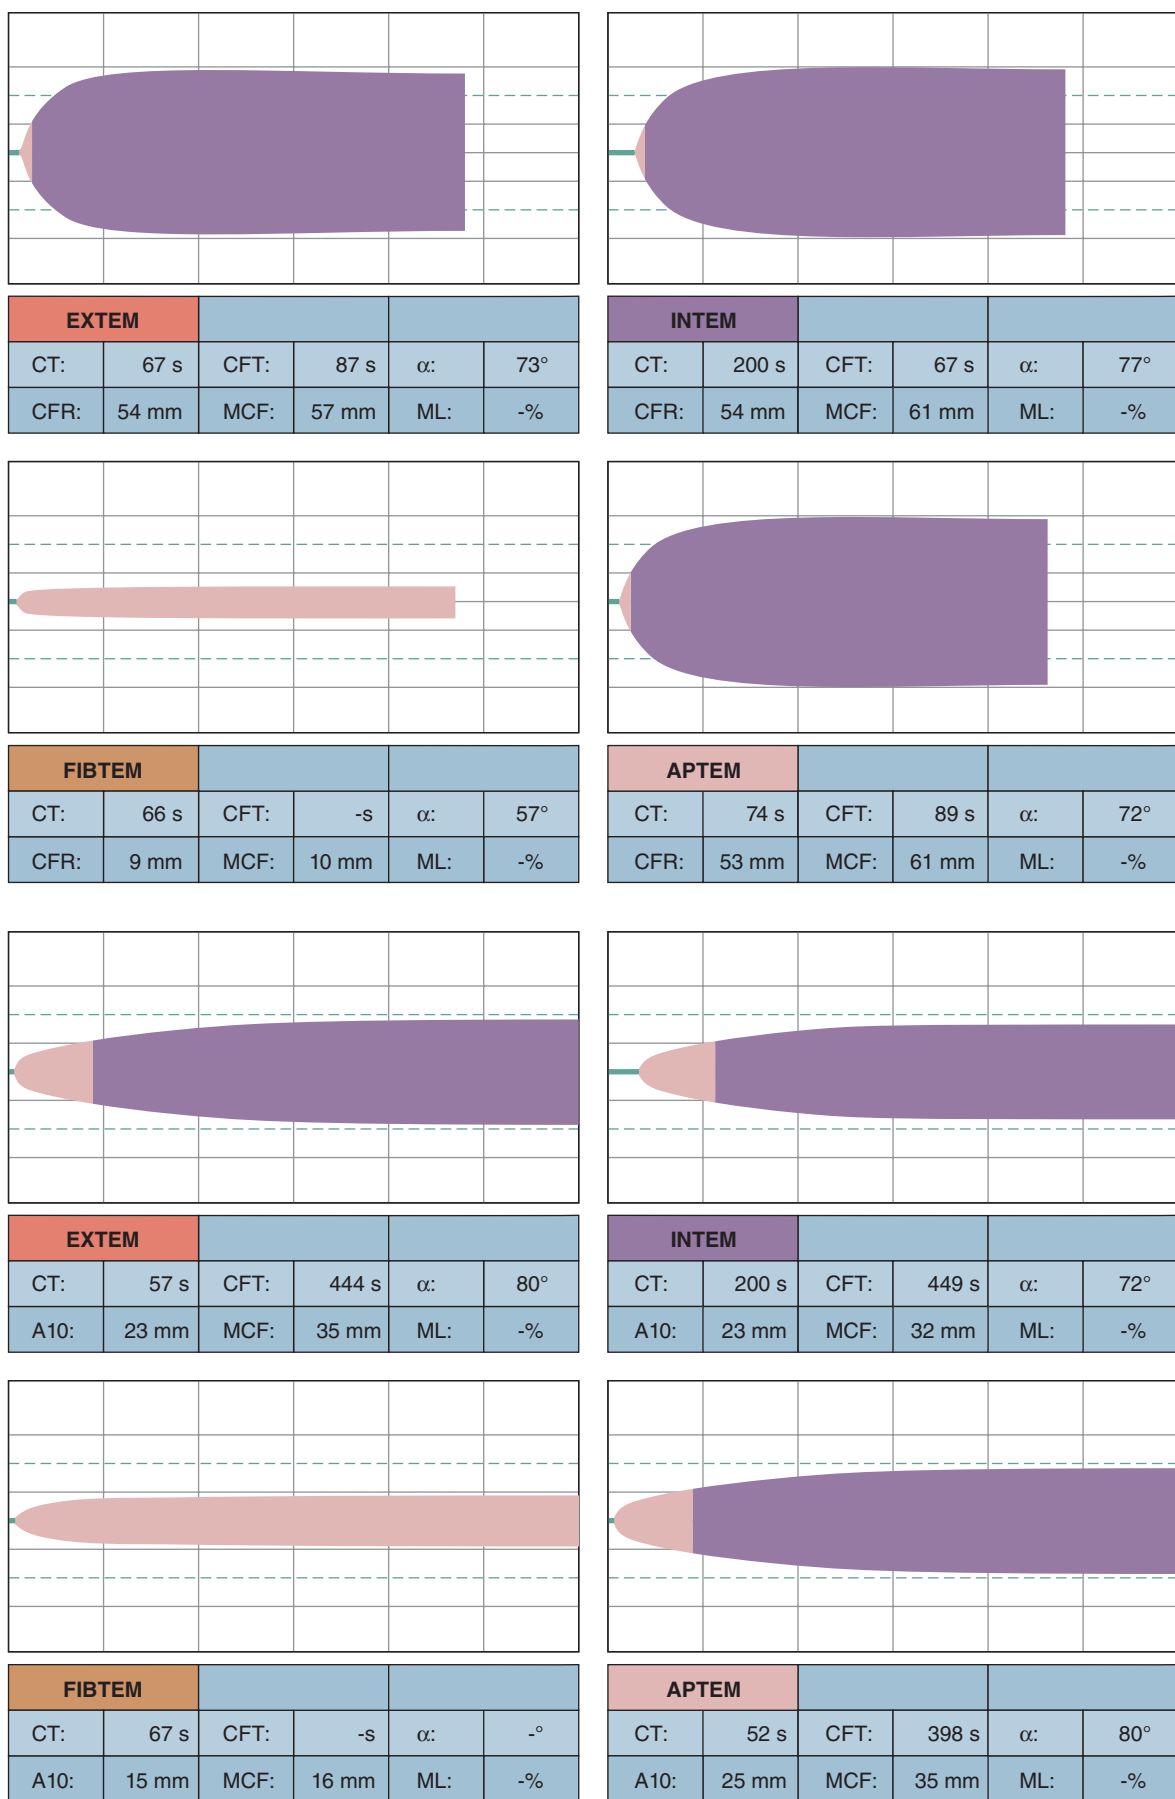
Left, Normal tracings for the four standard parameters in the rotational thrombelastometry (ROTEM, TEM Systems, Durham, NC) system. Right, Platelet dysfunction, which is demonstrated by the prolonged clot formation time (CFT), as well as a decreased maximum clot firmness (MCF) in both the extrinsic system (EXTEM) and the intrinsic system (INTEM) tests. A10, amplitude 10 min after CT; APTM, tissue factor activation + tranexamic acid/aprotinin; CFR, clot formation rate; CT, clotting time; FIBTEM, measure of fibrinogen activity.
